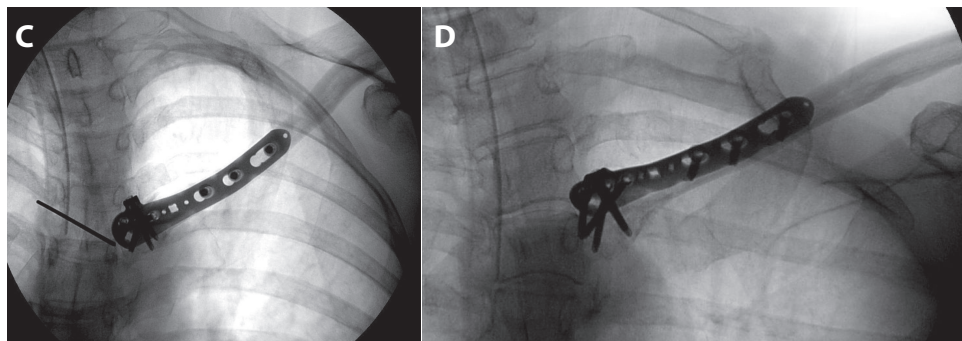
AND 1D. Intraoperative x-rays of open reduction and internal fixation with an antero-superiorly placed radial (VA)-LCP™ Distal Humerus Plate (DePuy Synthes, Switzerland) in a bridging technique through a longitudinal approach.
